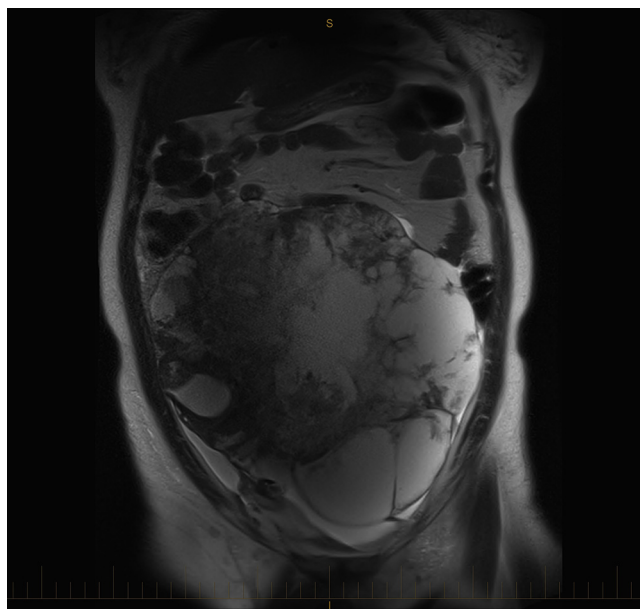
Coronal image of MRI scan demonstrating internal septations and nodularity of the KT.
